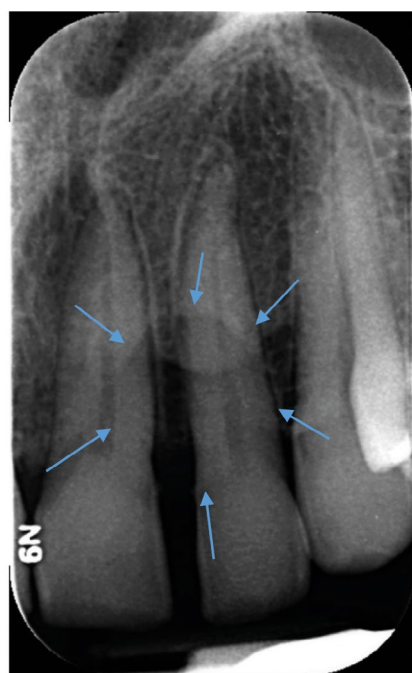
Periapical of the 22. Patient presented with a gingival swelling similar to a periodontal abscess and associated mobility of the tooth. Periapical shows no obvious horizontal bone loss or dental pathology. A faint soft tissue outline is evident (blue arrows) corresponding to the clinical swelling. Biopsy of the site confirmed a renal cell carcinoma metastasis
